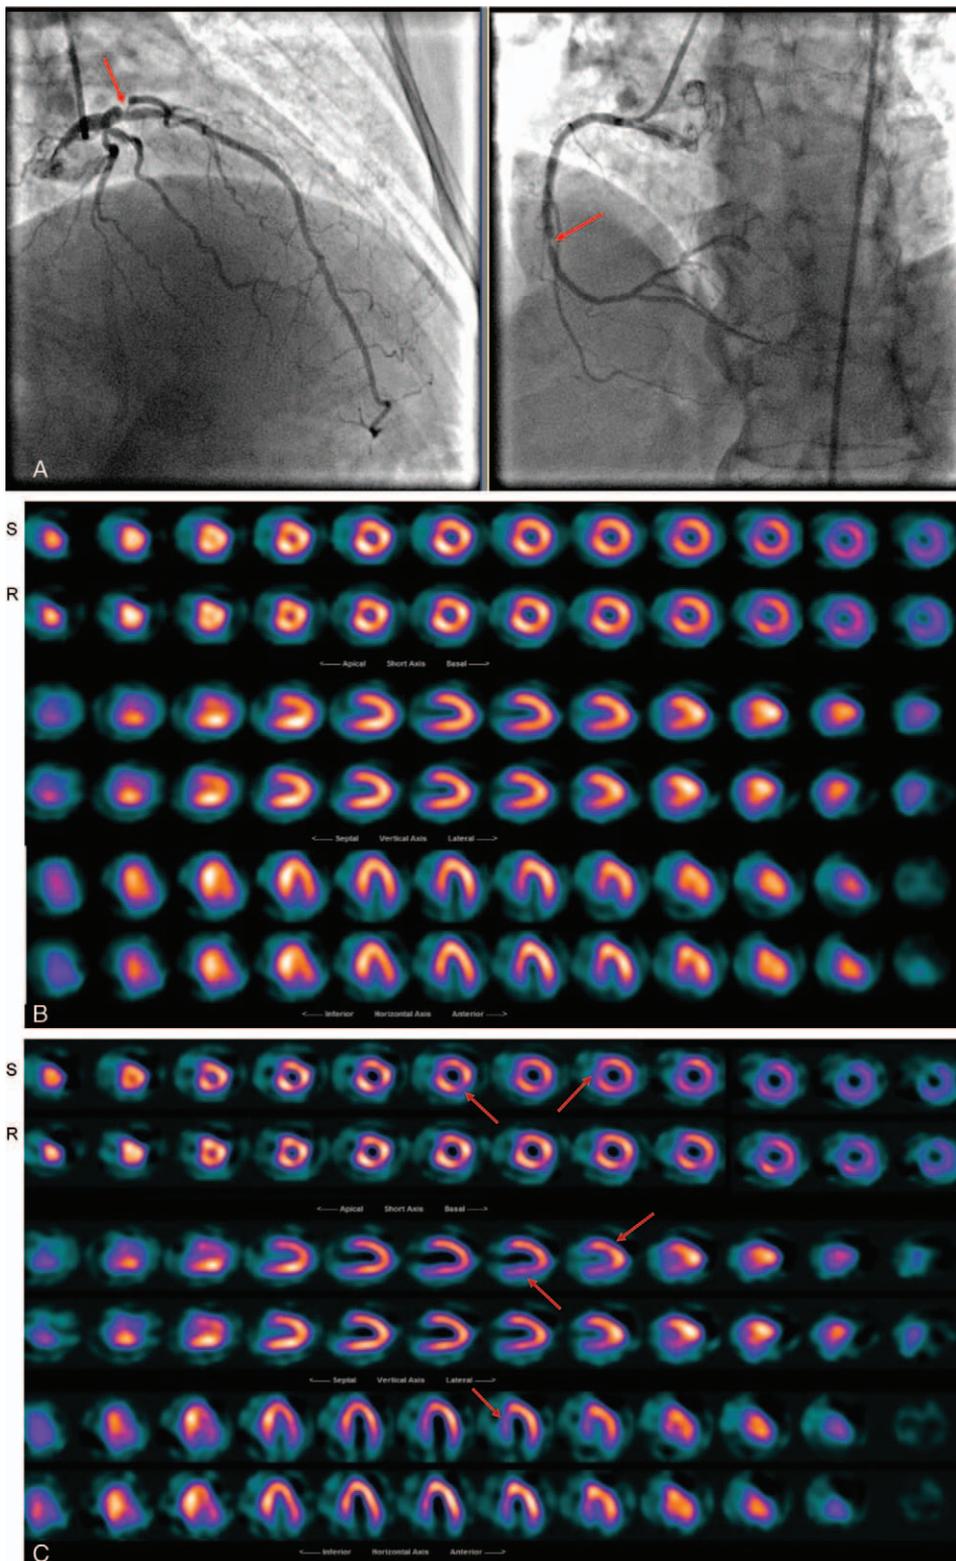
A 62 years old female patient with atypical chest pain and history of multiple PCI was referred to NM for evaluation of myocardial perfusion. (A): Angiography result reported triple vessels disease, (B): Butterworth reconstructed SPECT results reported negative myocardial ischemia, (C): Wiener reconstructed SPECT results suggested diffuse uptake in inferior wall, apical and mid anterolateral walls + cardiomyopathy in septal wall that was more consistent with the angiography. PCI = percutaneous coronary intervention, SPECT = single photon emission computerized tomography.
